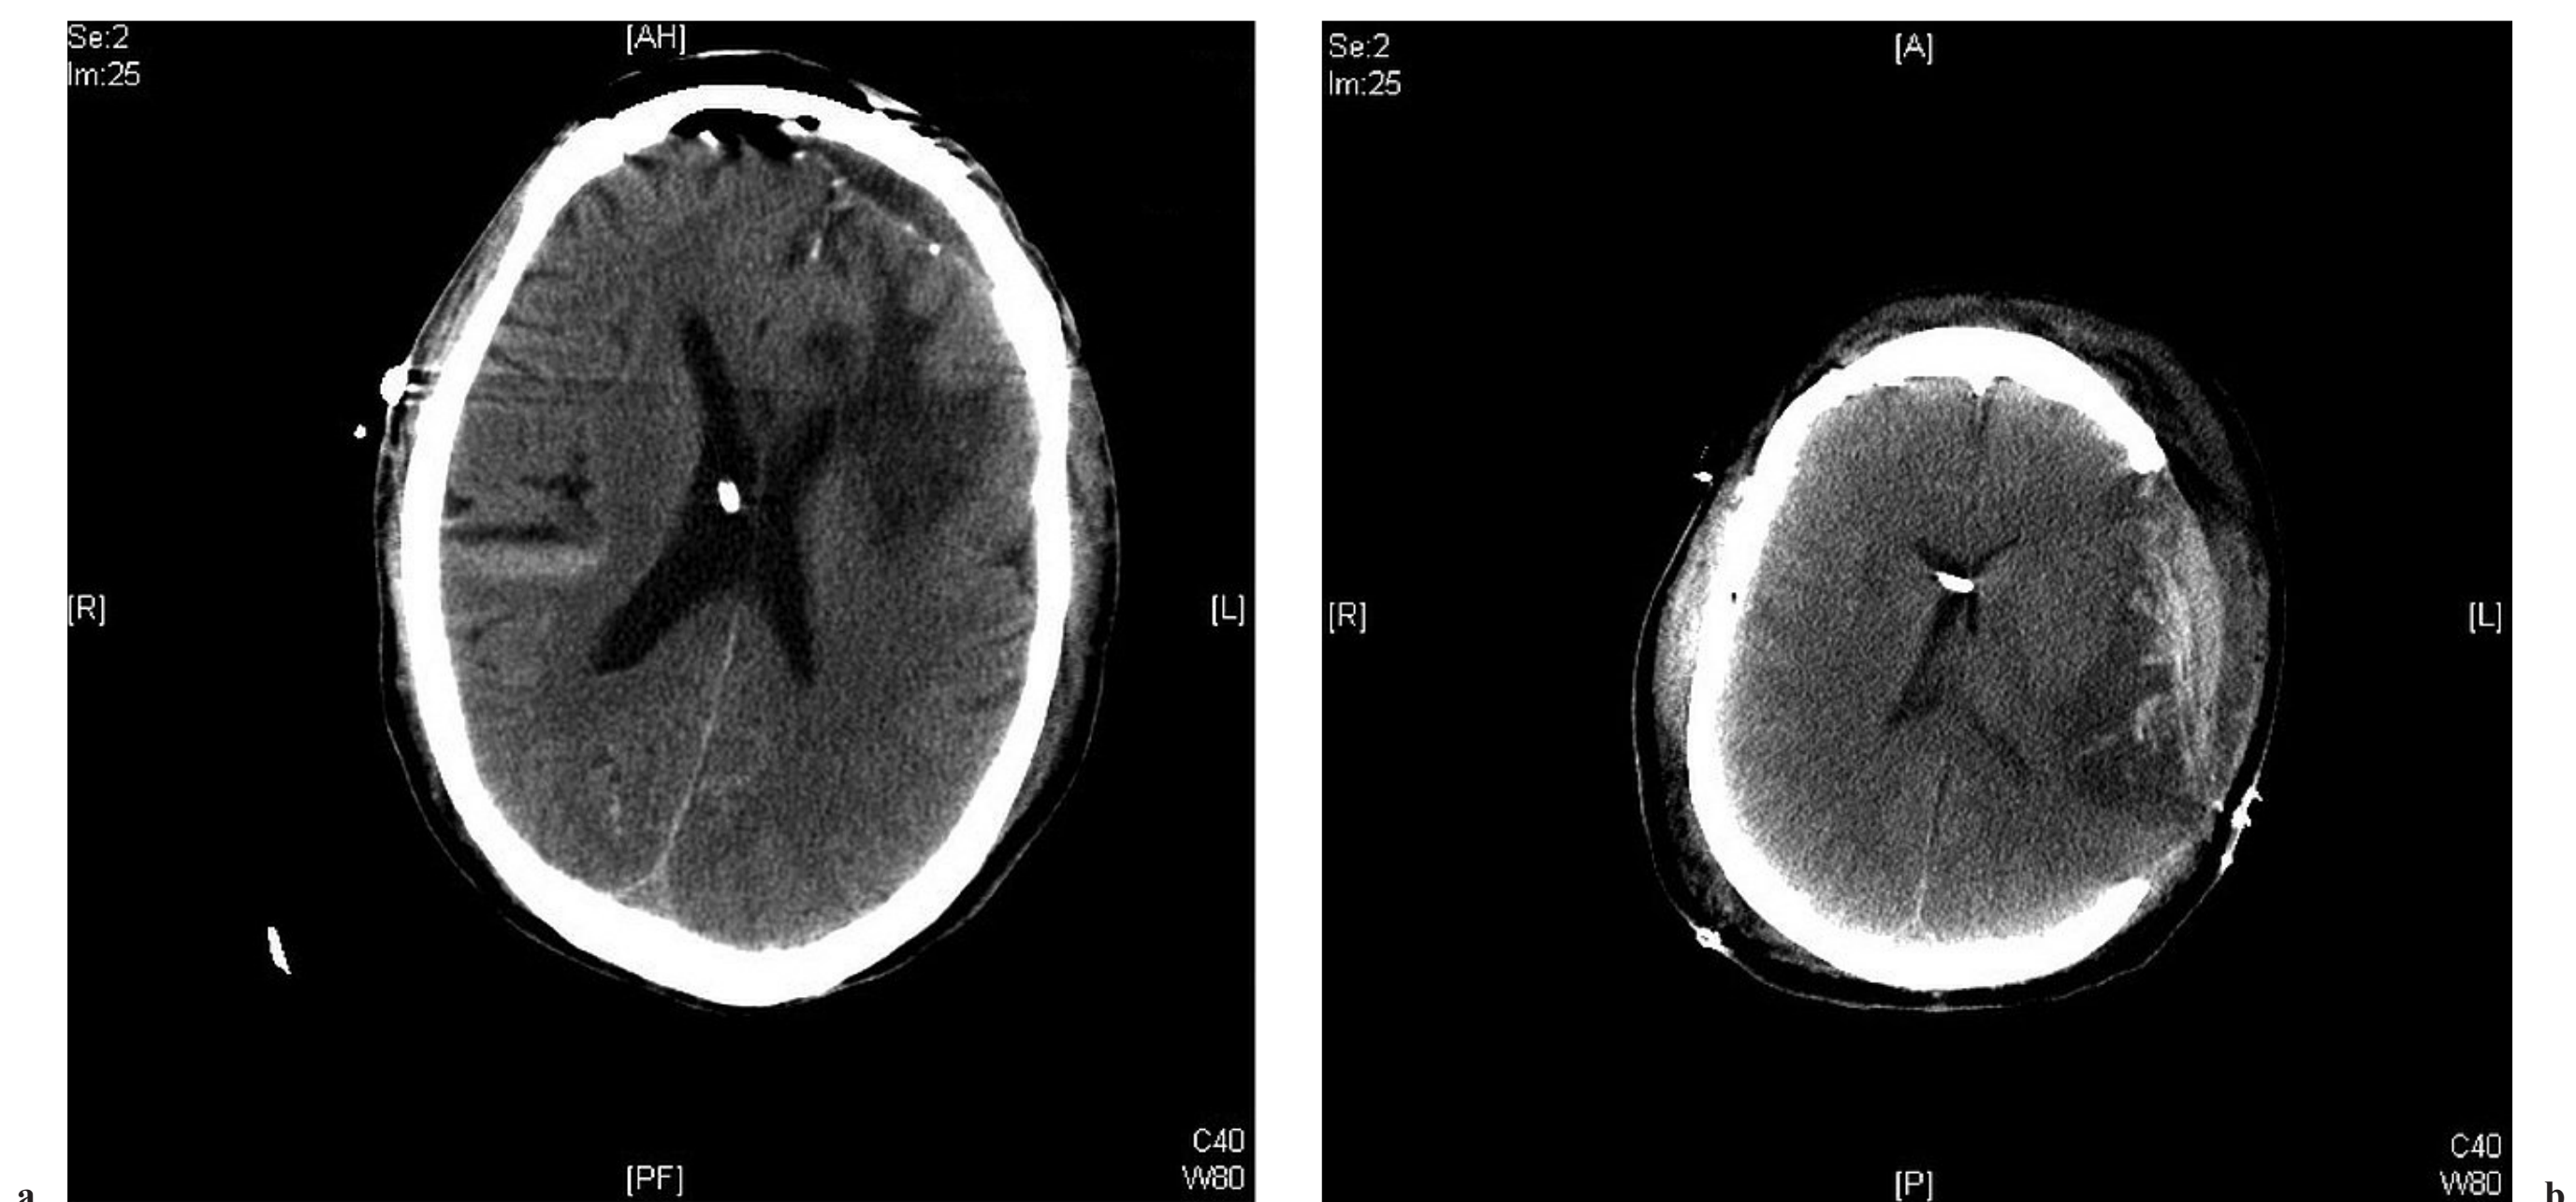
Axial CT images after evacuation of (a) frontal and (b) temporal lobe contusions. In each case, an external ventricular drain has been placed to facilitate monitoring of intracranial pressure and therapeutic drainage of cerebrospinal fluid.
